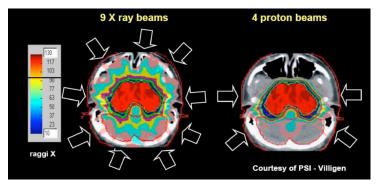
The comparison between two treatment plans of a large skull base tumour shows that normal tissues are much less irradiated when 4 proton beam are used instead than 9 X-ray beams.
